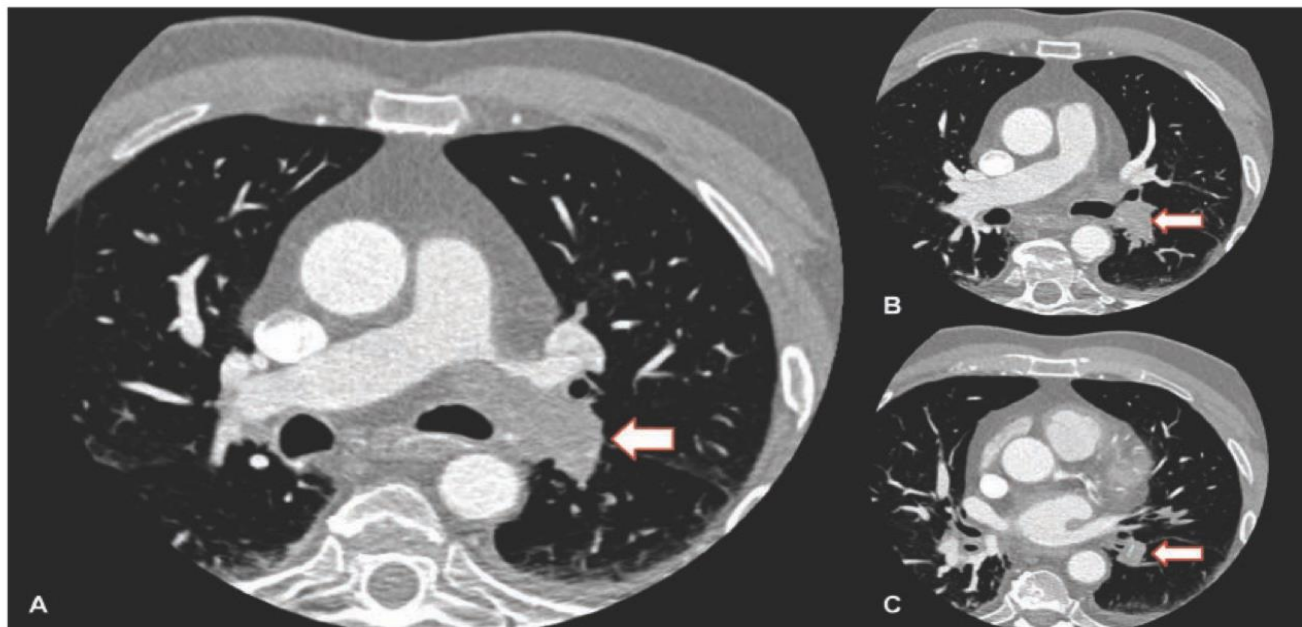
Coronary computed tomography angiograms in a 66-year-old man, showing multiple filling defects (arrows) in the left arterial pulmonary circulation, with a main lesion at the level of the left pulmonary artery.
